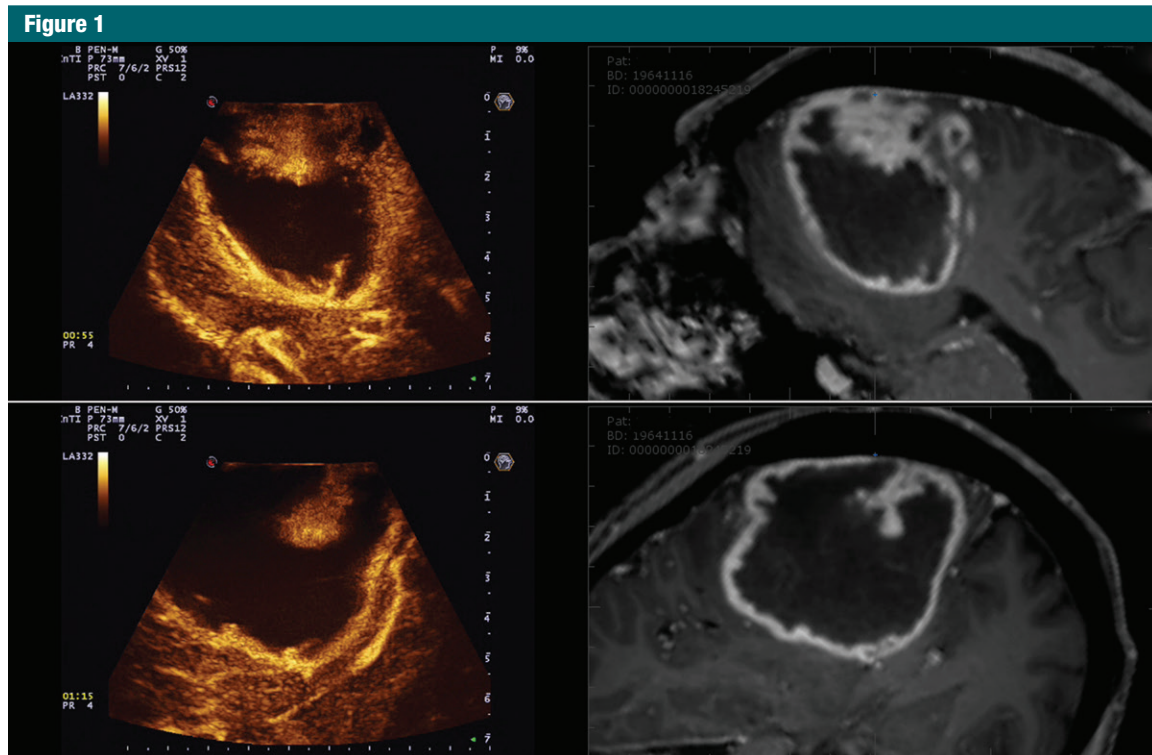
Navigation contrast-enhanced orthogonal US scans of left frontal GBM in 49-year-old woman. Top row, sagittal contrast-enhanced US scan (left) and corresponding coplanar preoperative MR image (right). Bottom row, coronal contrast-enhanced US scan (left) and corresponding coplanar preoperative MR image (right).
